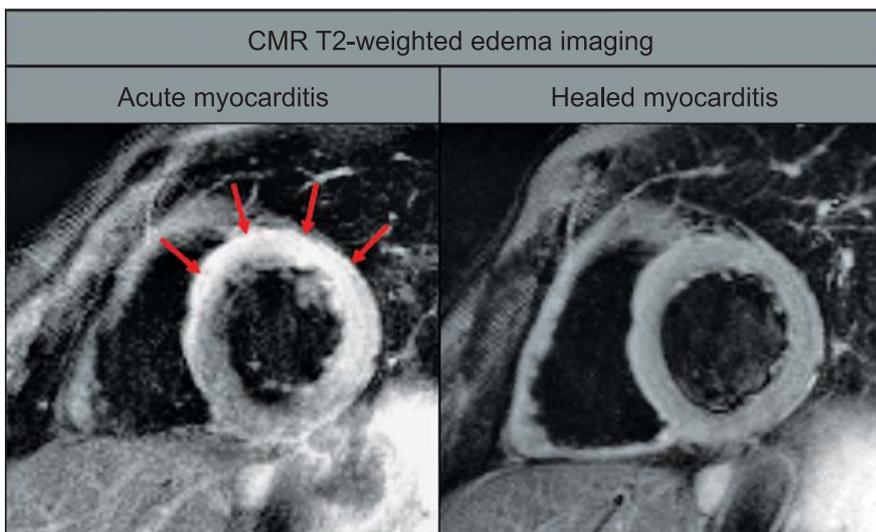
T2-weighted short-axis spin-echo images in a patient with biopsy-proven myocarditis during the acute phase of disease (left) and after three months of recovery (right). High signal intensity in the anteroseptal and anterolateral segments (red arrows) during the acute phase was indicative of myocardial oedema/inflammation and had already disappeared at follow up.
